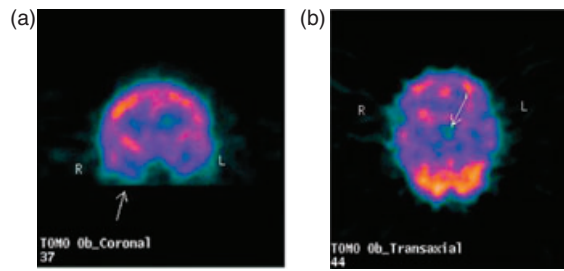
Coronal (a) and transaxial (b) brain 99m-Tc-ECD SPECT scans showing more marked right mesiotemporal (a) and thalamic (b) hypoperfusion.
